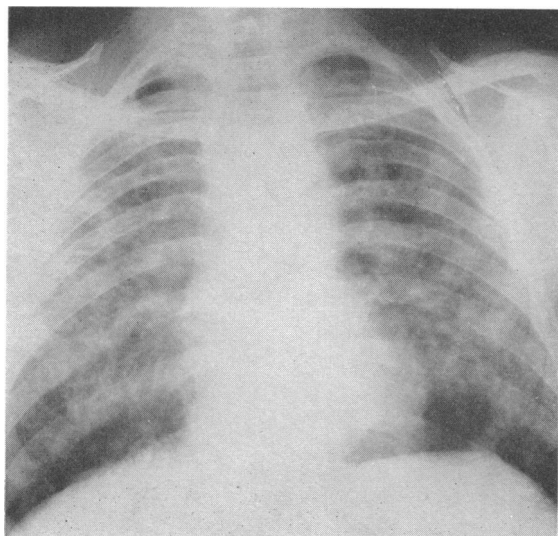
Case 5. Radiograph of chest, November, 1950.
